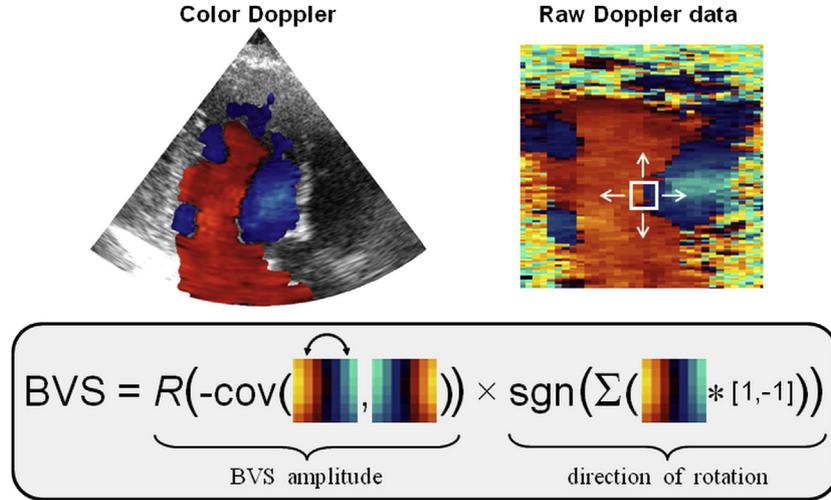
Blood vortex signature. The blood vortex signature (BVS) is calculated using a small block sliding over the raw color Doppler array. The local BVS is based on the covariance (cov) between this block and its antisymmetric counterpart. The rotation direction is determined using a simple convolution.  $R$  and  $\text{sgn}$  stand for the ramp and sign functions, respectively.
